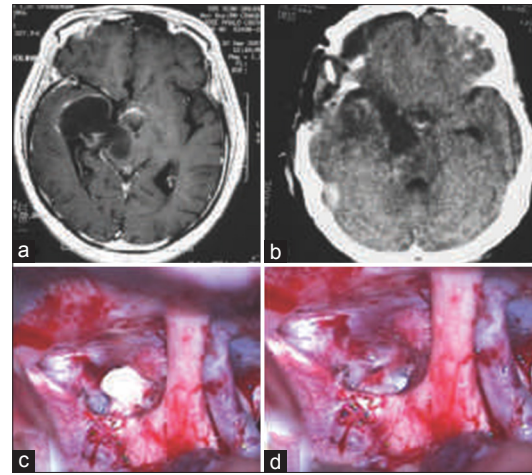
(a) Axial T1-weighted MRI scans with contrast enhancement demonstrating a large, hypointense frontal-temporal, retrochiasmatic lesion with significant compression of the midbrain. (b) Postoperative CT scans revealing near-total tumor resection with decompression of the brain stem and removal of the retrochiasmatic portion of the tumor. (c) Operative photographs displaying the retrochiasmatic portion of the lesion. (d) Operative view demonstrating complete removal of the retrochiasmatic fragment
